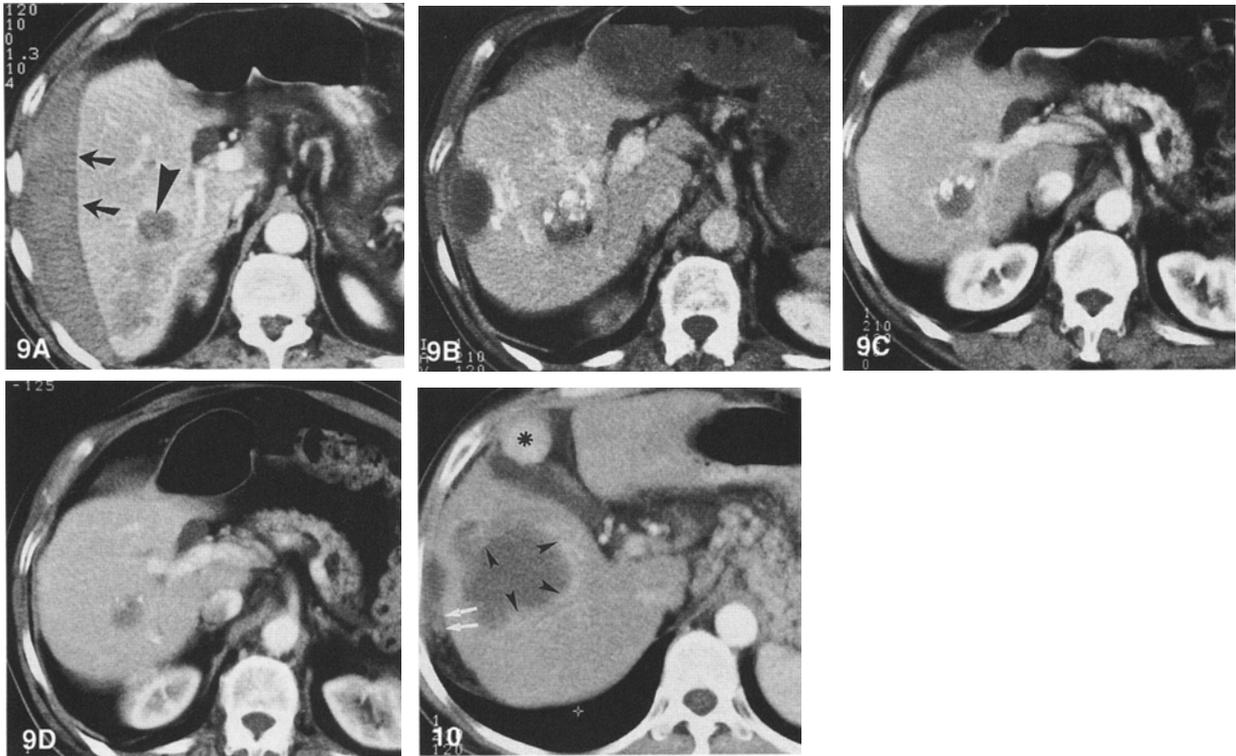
Long-term follow-up after PEI of a small HCC in a noncirrhotic liver. A Contrast-enhanced spiral CT image shows a 3-cm HCC in the right lobe of a noncirrhotic liver (arrowhead). The tumor became manifest due to massive subcapsular hemorrhage (arrows) and a biopsy was done after spontaneous resolution of the hematoma. The serum alpha-fetoprotein level was significantly elevated. B Contrast-enhanced spiral CT image obtained immediately after PEI. Some densely hyperattenuating areas within the lesion are due to previous angiography with injection of iodized oil. Note the residual subcapsular hematoma. After three sessions of PEI, the alpha-fetoprotein levels became normal and remained so during further follow-up. C, D Contrast-enhanced spiral CT images show the lesion 7 months and 2.5 years after PEI; there was no evidence of tumor growth.
